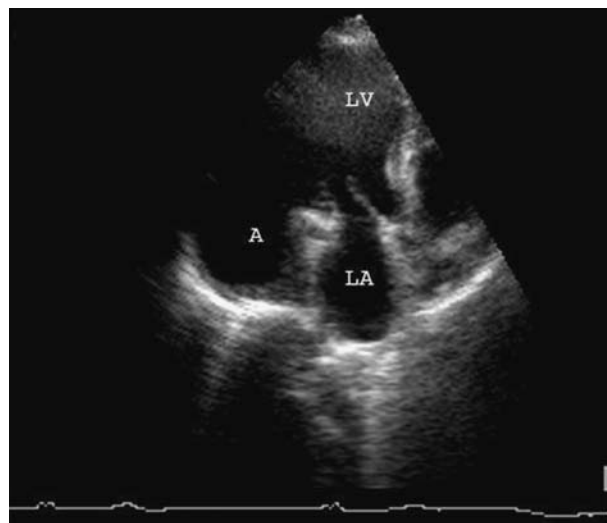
Transthoracic echocardiography shows the inferolateral aneurysm.
